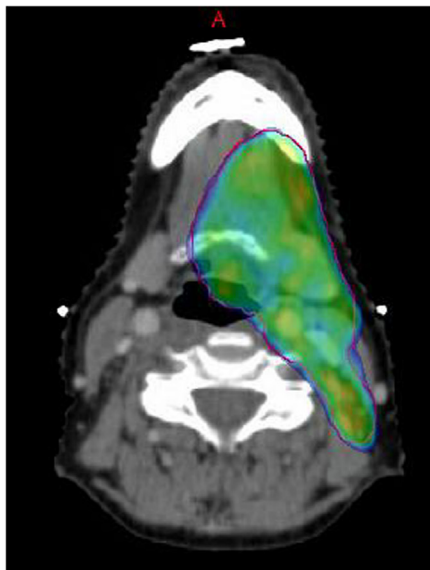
Example of 95% dose distribution between the synthetic CT and planning CT1 at fraction 16.
